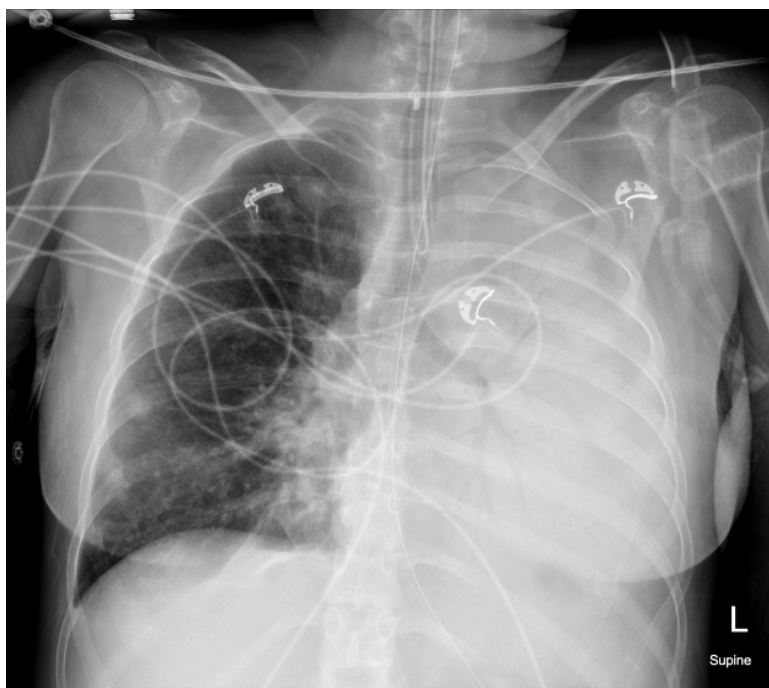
Chest X-ray showing a clear air bronchogram sign
